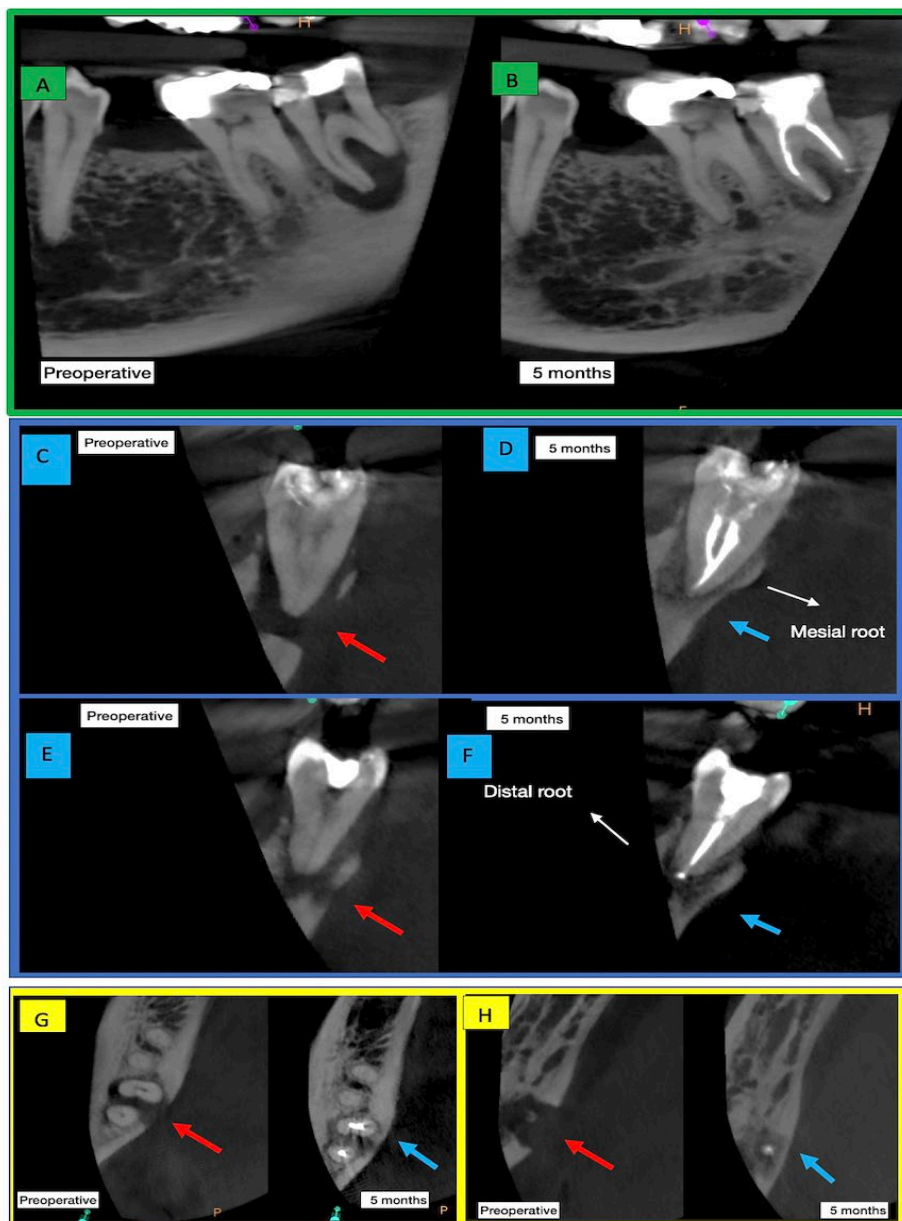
Comparative CBCT images of case 2 (preoperative and after 5 months); A, B) Sagittal images; C, D, E, F) Coronal images; G, H) Axial images at cervical and apical thirds respectively; The red arrows indicate the osteolytic lesion (preoperative) and the blue arrows the bone recovery (postoperative 5 months after)
